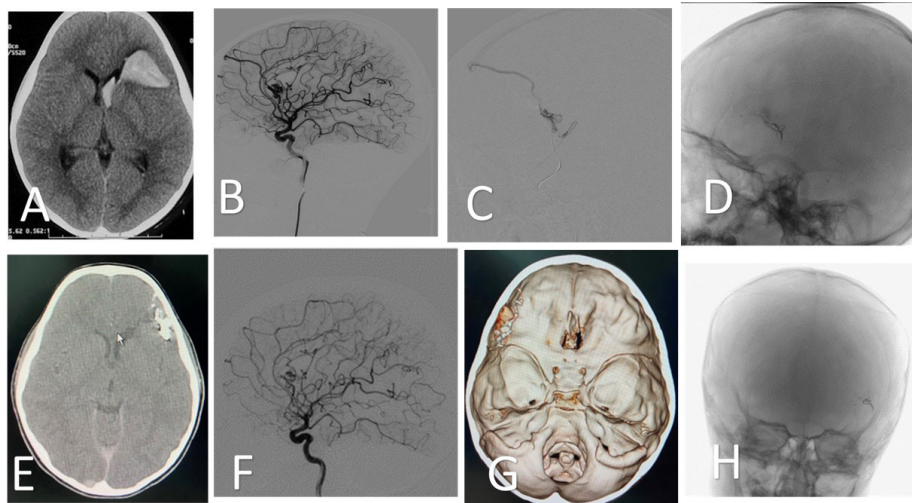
Male child, 8 years old, presented with left frontal ICH with intraventricular extension. CTA shows small frontal AVM. Endovascular embolization performed in one session with total obliteration of AVM. (A) CT brain at onset shows ICH with intraventricular hemorrhage (B) Pre-embolization lateral left carotid angiogram shows the feeding artery (anterior cerebral artery), nidus and draining vein (C) Super-selective catheterization of the feeding artery (D) Onyx cast in the 1st view takes same configuration of the nidus (E) Onyx cast in post-embolization CT with complete resolution of the hematoma (F) Post-embolization lateral left carotid angiogram shows total obliteration of AVM (G) Onyx cast in post-embolization 3 dimensions bone window CT (H) Onyx cast in X-ray anteroposterior view.
